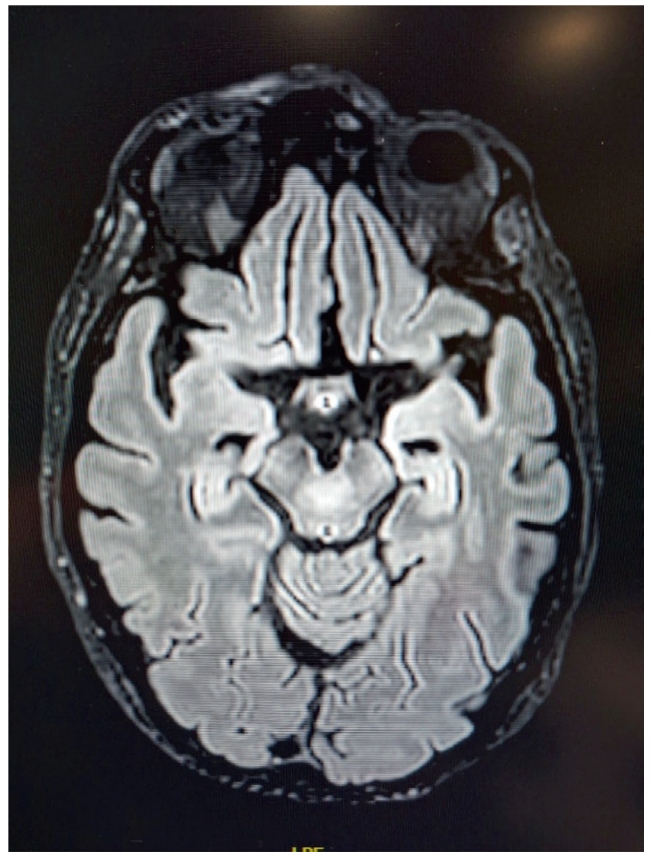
Brain MRI of the first patient showed multiple white matter hyperintensities in T2 and FLAIR in midbrain, pons, both thalami, compatible with IgLON5 encephalitis.
